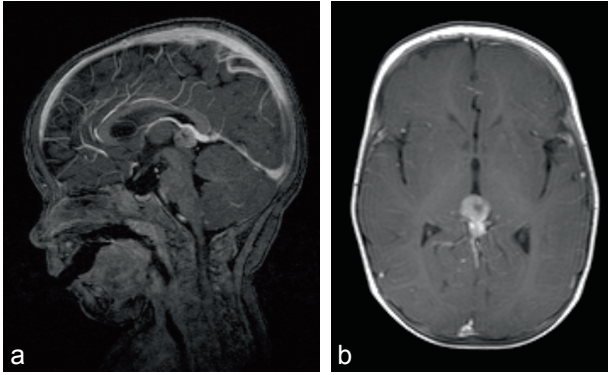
Patient 5, a 10-month-old with hereditary retinoblastoma and pineoblastoma. *A*, Sagittal T1-weighted postgadolinium MR image shows a cystic mass in the pineal gland. *B*, Axial T1-weighted image shows an asymmetric nodular thickening of the tumor wall. The thickness of the enhancing wall varies from 3 to 7 mm, suspicious for pineoblastoma.
